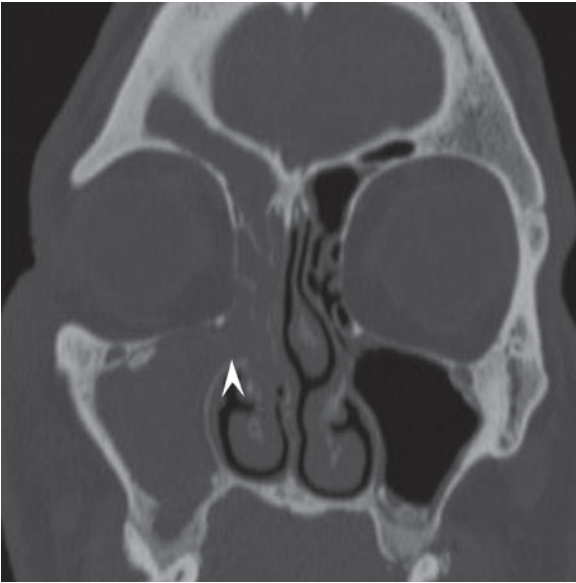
Middle meatus syndrome. Coronal CT shows unilateral opacification of the maxillary, ethmoid, and frontal sinuses. Note the widened infundibulum (*arrowhead*) that indicates the offending antranasal polyp
